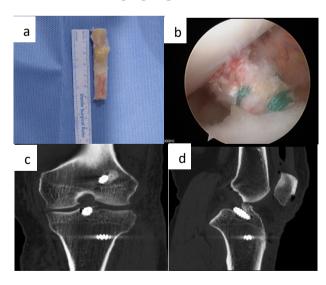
(a) Intraoperative photo of short BPTB graft 63 mm. (b) Arthroscopic image showing reconstructed ACL using BPTB graft. (c) Coronal CT SCAN showing proximal graft migration. (d) Sagittal CT SCAN showing intraarticular bone plug migration.
